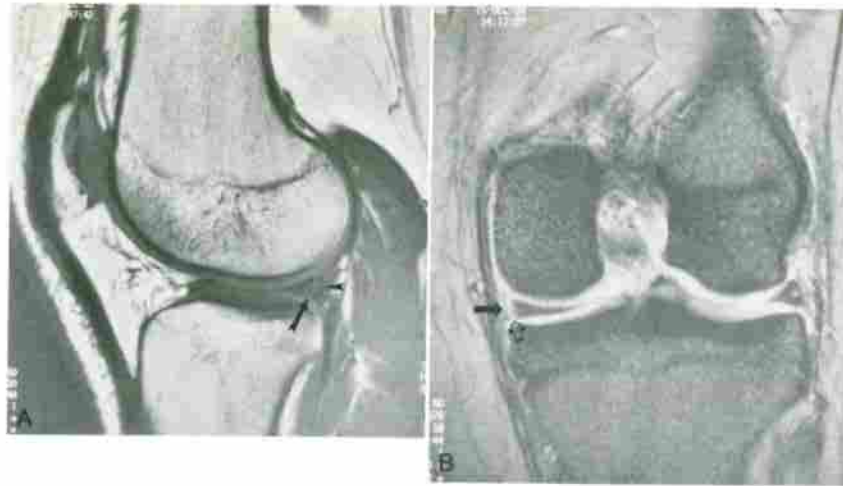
Meniscocapsular separation. A, T1-weighted (TR/TE, 430/20) sagittal image of medial meniscus shows a vertical high-signal-intensity tear (arrow) through the most peripheral aspect of the posterior meniscus. A fragmented small segment of the meniscus (arrow-head) is separated from the remainder of the posterior horn. B, Coronal gradient echo (TR/TE, 578/18; angle, 30 degrees) image again demonstrates the vertical tear (open arrow) and small detached fragment (solid arrow) with increased conspicuity, confirming the diagnosis.
